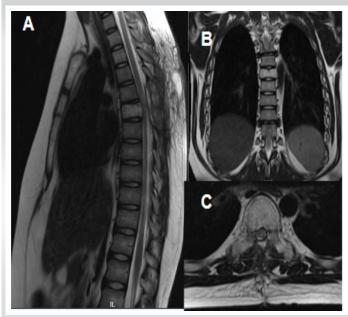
Magnetic resonance imaging: Signs of decompression, including laminectomies and resection of the spinous processes at the T5 and T6 levels. There is a significant reduction in the amplitude of the cerebrospinal fluid space, especially at the T6 level, and a slight increase in T2 signal intensity in the dorsal spinal cord at this level, without significant change in spinal cord thickness.
